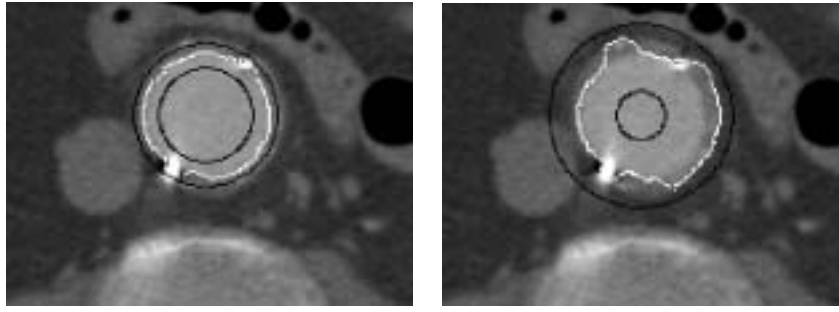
Example CTA slice showing the boundaries of the polar plot (black) and the contours detected (white). If the region in which the contour is searched is taken larger, part of the thrombus boundary is included in the detected optimal path.
